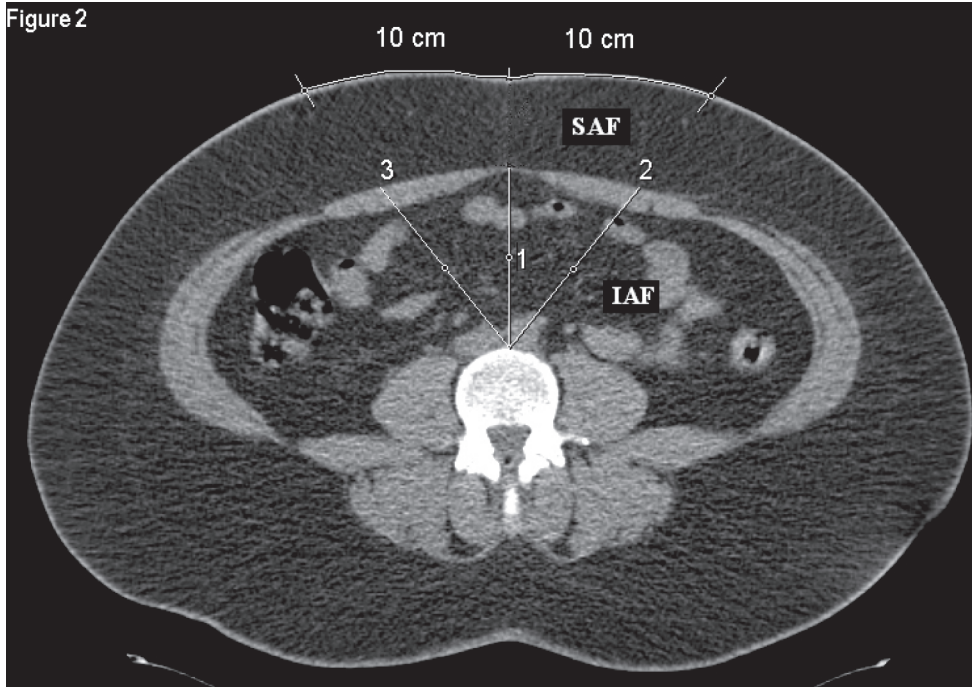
Example of a CT scan showing the intra-abdominal fat (IAF) and the subcutaneous abdominal fat (SAF). The lines 1, 2 and 3 indicate the location of the distance measurement of IAF midline, left and right, respectively.
